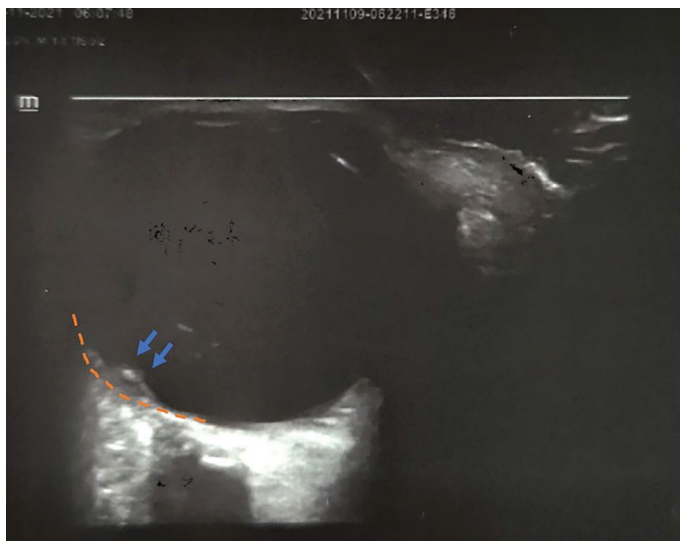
Ultrasonographic appearance of optic disc edema. Representative ocular ultrasonography image demonstrating optic disc elevation consistent with optic disc edema. The area protruding from the optical disk boundary, indicated by two blue arrows and orange dashed lines, is the optical disk elevation
